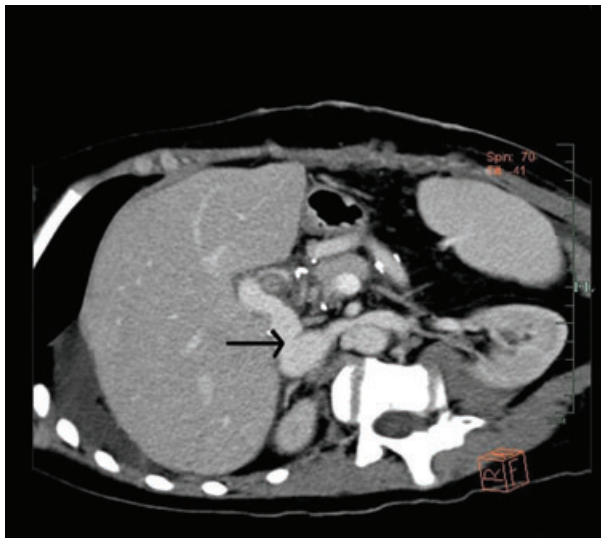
CT venography following re-OLT showing cavoportal hemitransposition with the donor portal vein (arrow) anastomosed to the caval vein of the recipient at the level of the left renal vein.
